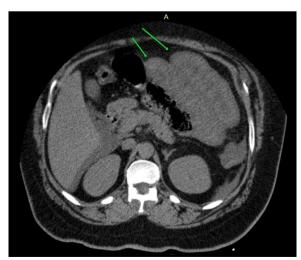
Non-contrast CT scan axial view showing dilated bowel loops with marked mucosal thickening of their walls in addition to hepatorenal and subhepatic free fluid
